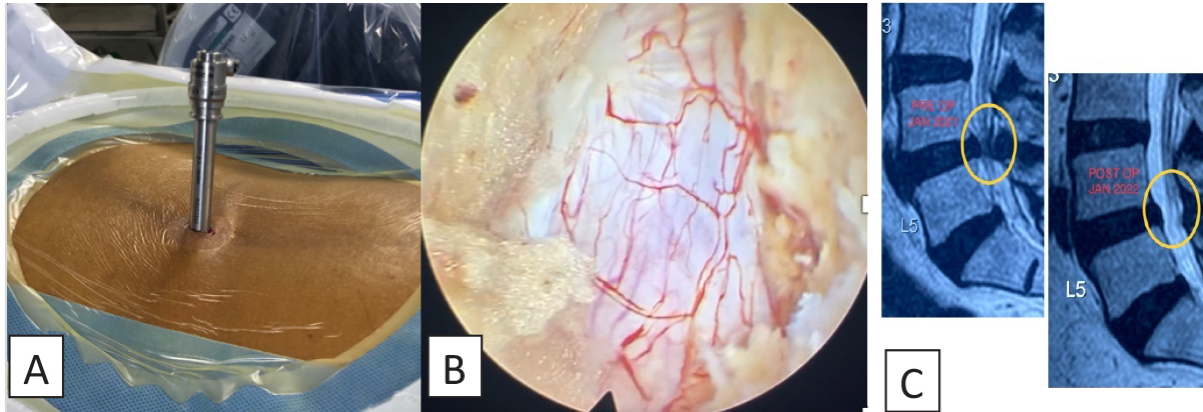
Full Endoscopic stenosis surgery. (A) Stenosis sheath insertion, (B) Endoscopic decompression ipsilateral and over the top decompression done, (C) MRI T2WI showing decompression of the canal achieved in sagittal imaging, (D) axial T2WI MR showing comparison of pre and post-operative decompression (E) X-ray images showing widened canal post-decompression.
